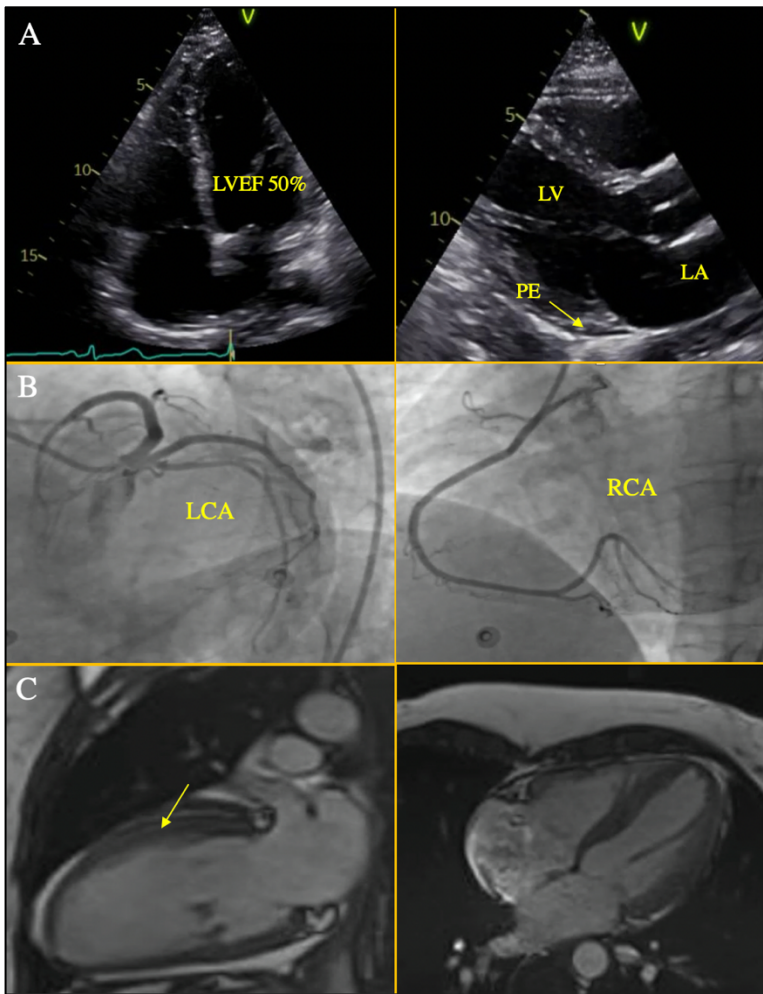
A) Trans-thoracic echocardiography showing preserved left ventricular function, normal atrial and ventricular dimensions, pericardial effusion of 3 mm, no cardiac masses; B) coronary angiography showing no coronary lesions; C) cardiac magnetic resonance showing anterior and lateral wall hyperintensity with presence of shaded late gadolinium enhancement. LA, left atrium; LCA, left coronary artery; LVEF, left ventricular ejection fraction; LV, left ventricle; PE, pericardial effusion; RCA, right coronary artery.
